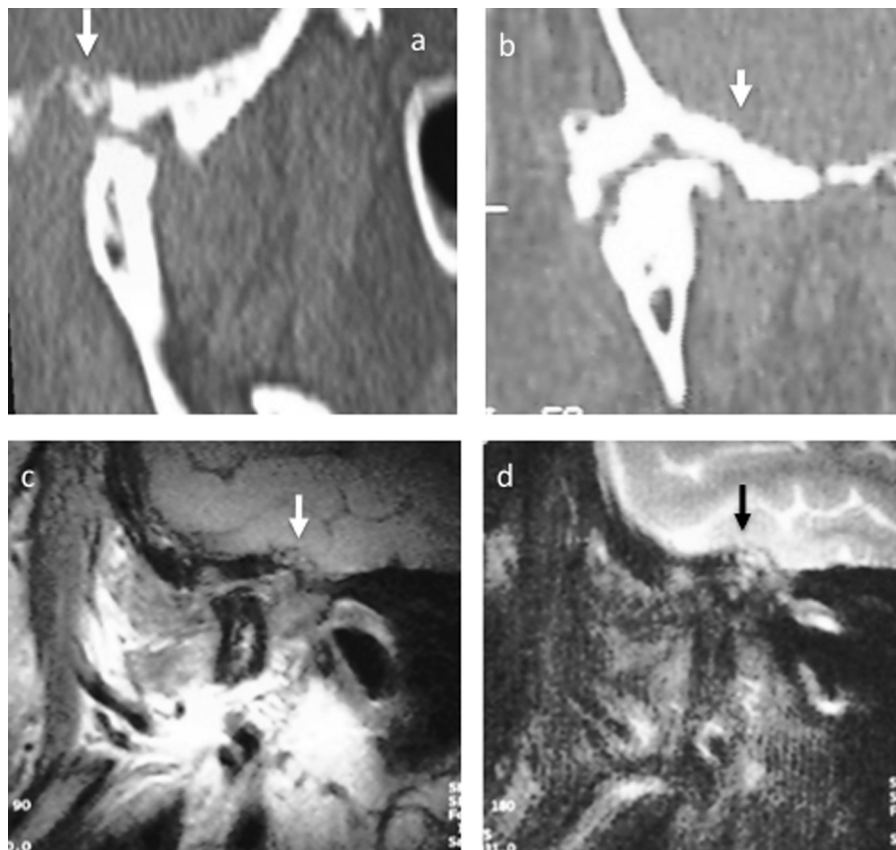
(a–d) CT (a,b) and MRI (c,d) at 6 months after surgery. Arrows indicate new bone formation of the glenoid fossa. (a,b) Images reproduced from Ref. [11].
